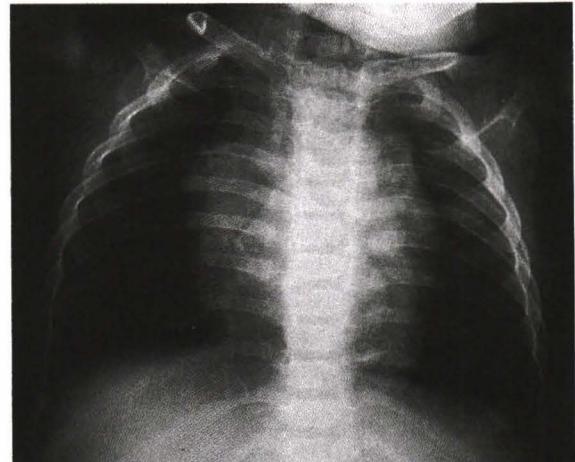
Chest X-ray shows total improvement of multiple lung cysts at 1 year old.
